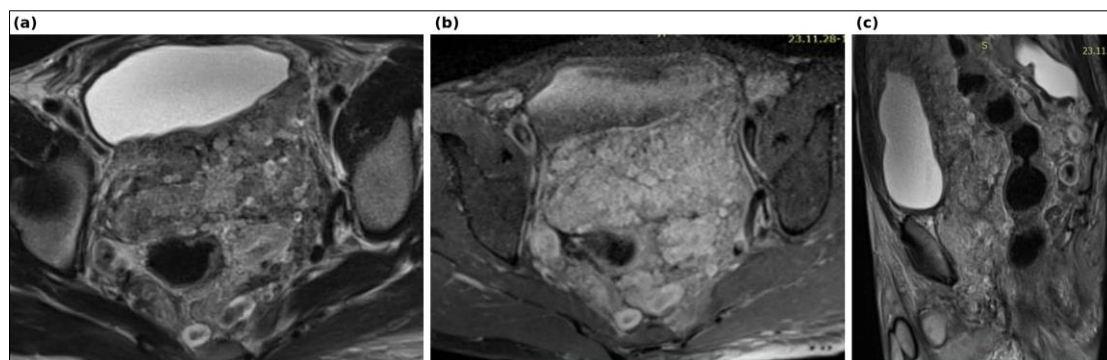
Pelvic MRI in axial T2 (a), T1 after gadolinium injection (b), and sagittal T2 (c): Heterogeneous retroperitoneal mass, predominantly hyperintense in T2 sequences with a hypointense center ("ring" appearance) with slight central enhancement in T1+ gadolinium sequence
